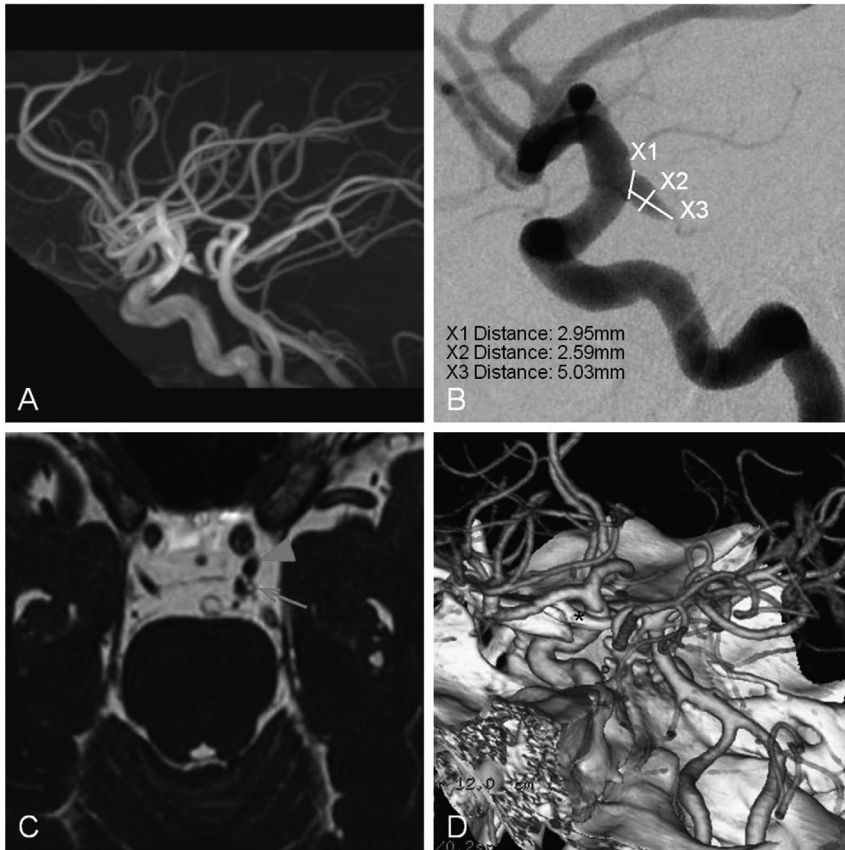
Lateral preoperative magnetic resonance angiography (A) and digital subtraction angiography of the left internal carotid artery (B) showing a funnel-shaped dilatation. C: Preoperative fast imaging employing steady-state acquisition showing a contact point between the oculomotor nerve (*arrow*) and the infundibular dilatation (ID) (*arrowhead*). D: Postoperative three-dimensional computed tomography scan showing the aneurysm clip (*asterisk*) and disappearance of the ID.
